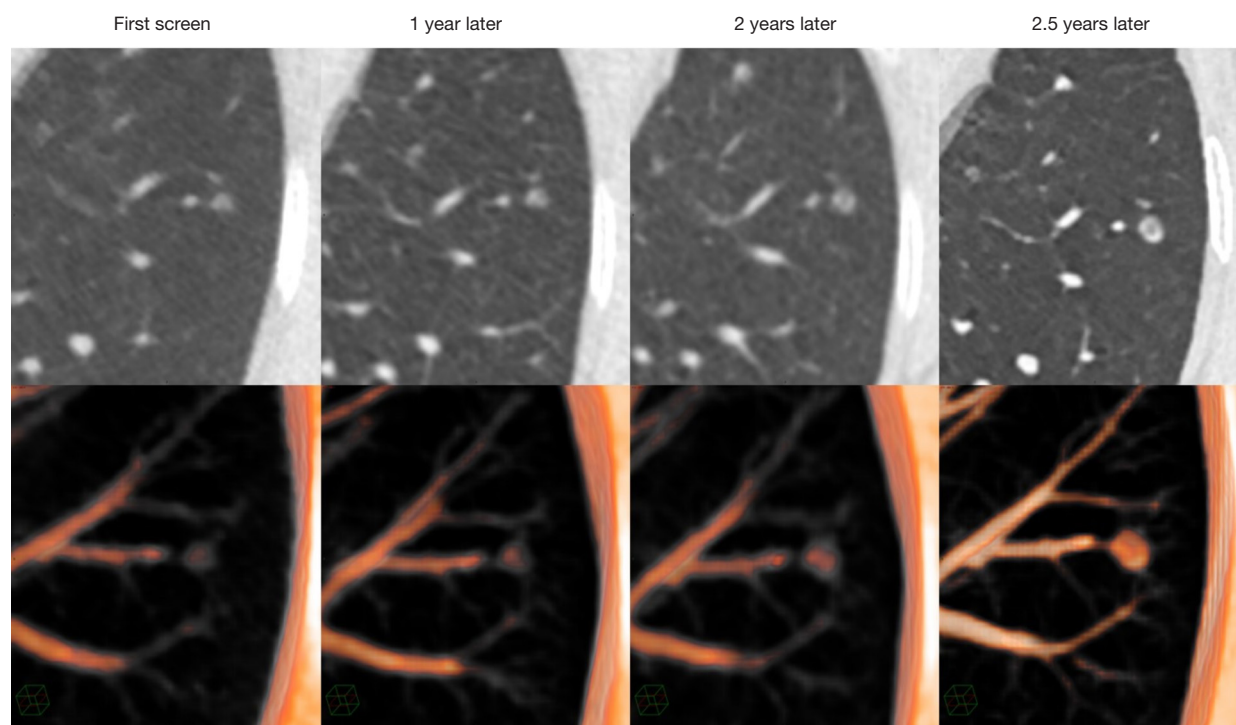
A 58-year-old woman with IA. A solitary GGN on the left upper lobe was first found during her health checkup. The nodule was followed up at 1, 2, and 2.5 years after the baseline CT. MPVR images showed that the size and density of the nodule were gradually increasing and the solid component in the nodule was gradually increasing and replacing the ground-glass part as time went by. MPVR images of the latest CT showed solid component size was 5.3 mm, which was finally confirmed as IA after an operation. IA, invasive adenocarcinoma; GGN, ground-glass nodule; CT, computed tomography; MPVR, multiplanar volume rendering.
